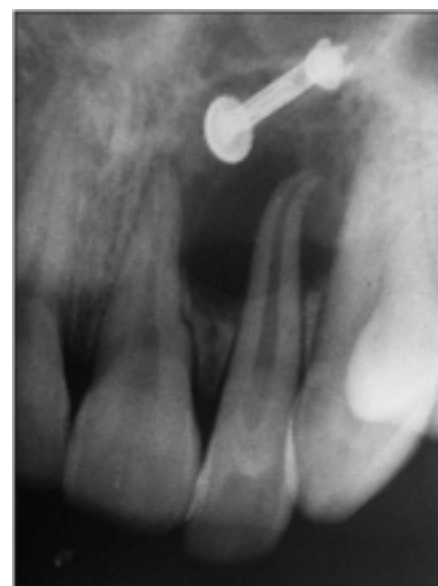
IOPA radiograph of maxillary left lateral incisor showing radiolucency at the root apex.
